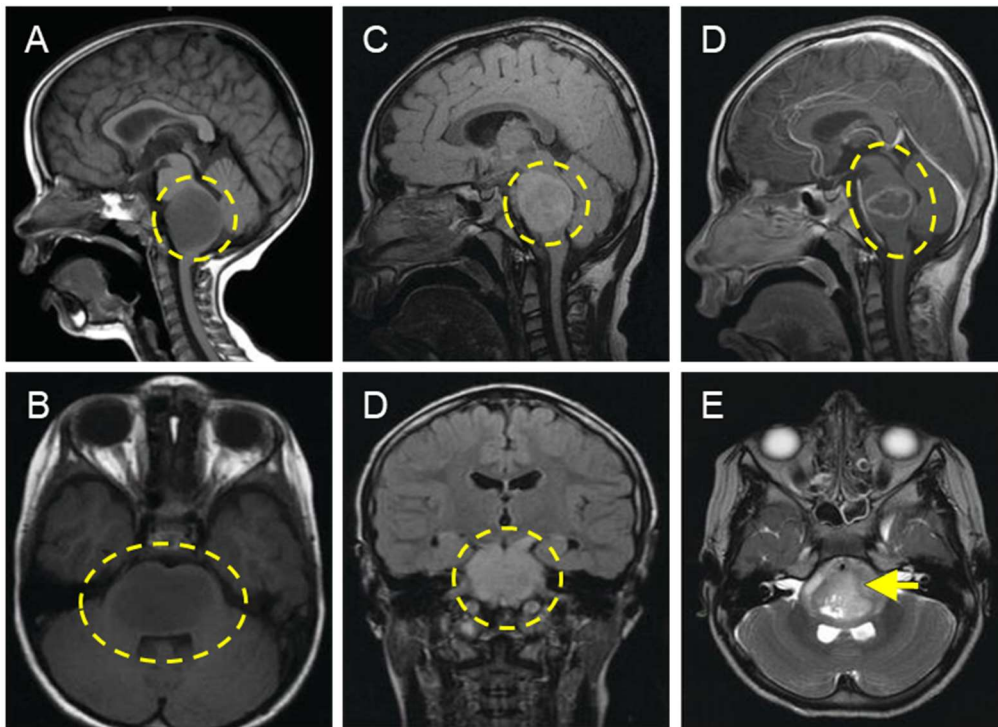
Classical MRI appearance of a DMG-infiltrated brain. (A) Sagittal and (B) axial T1-weighted pre-contrast MRI images showing an expansive, poorly margined and hypointense lesion in the pons. (C) Sagittal and (D) coronal images of a T2-weighted/FLAIR where the tumor presents an hyperintense signal. (E) Minimal post-gadolinium enhancement. (F) Basilar artery engulfment by the tumor (yellow arrow). Adapted from *Valvi and Gottardo, 2018*³².
